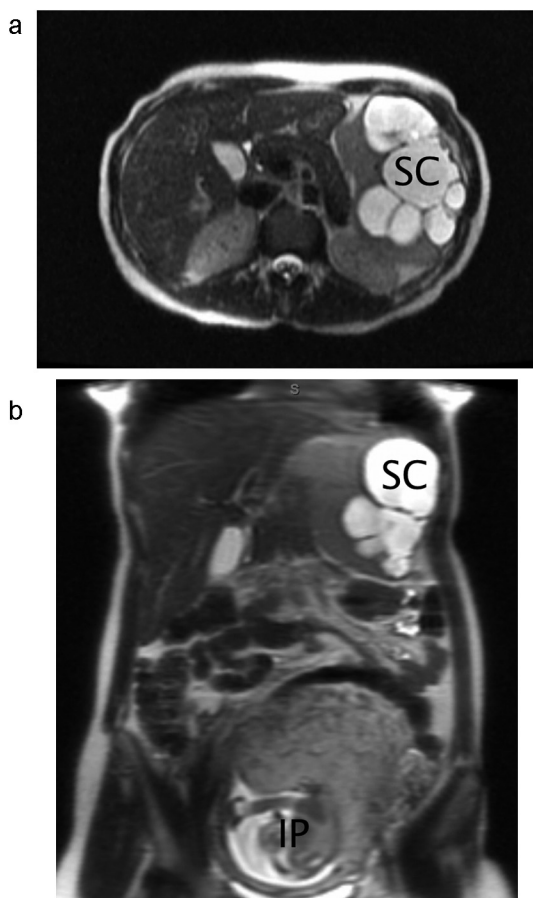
(a) MRI (axial) of splenic cyst (SC). (b) MRI (coronal) of splenic cyst (SC) also demonstrating the intrauterine pregnancy (IP).
